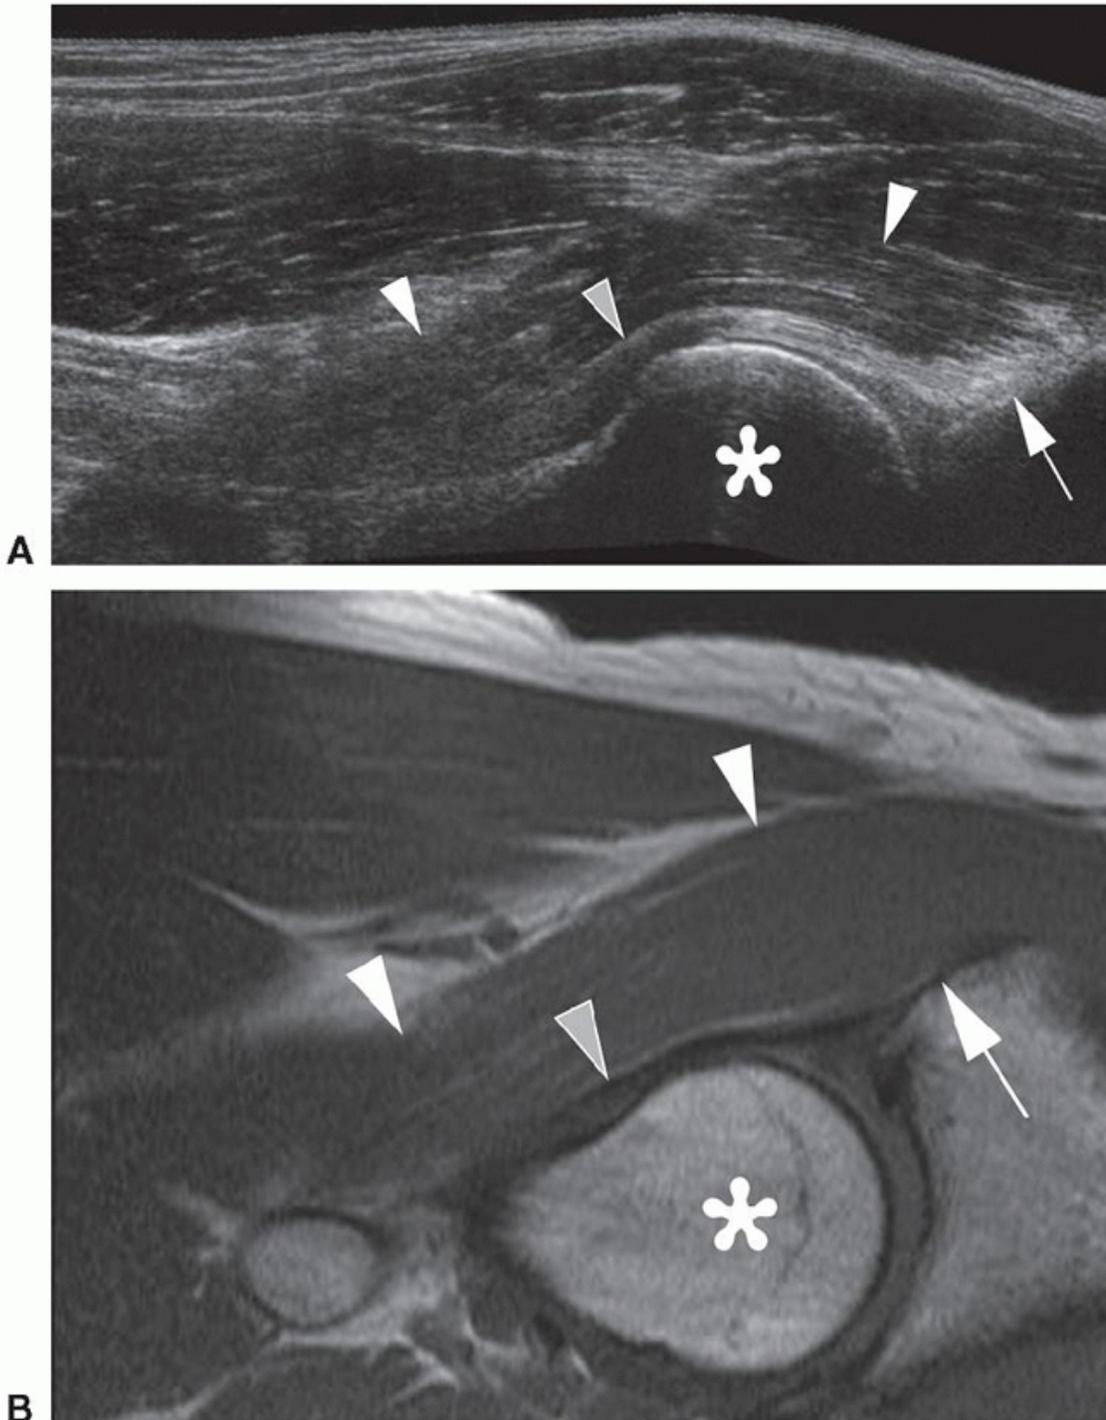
Normal LS views of the hip. A: Longitudinal sonogram and B: Sagittal T1-weighted (T1W) MRI show femoral head (asterisk), iliopsoas (white arrowheads), normal capsule (gray arrowhead) and acetabular rim (white arrow).
